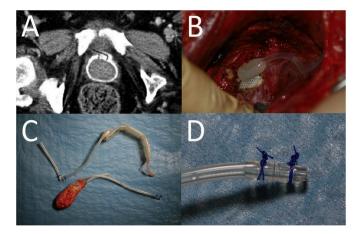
A) The 9 cm cuff (white round structure) seen in the middle of the CT image with air in the tube (black) indicating that the AUS system is defect. B) Bladder neck cuff and connector in-situ without signs of infection. C) Cuff still intact after 30 years in-situ. D) Broken tubing site at polypropylene suture connector.
